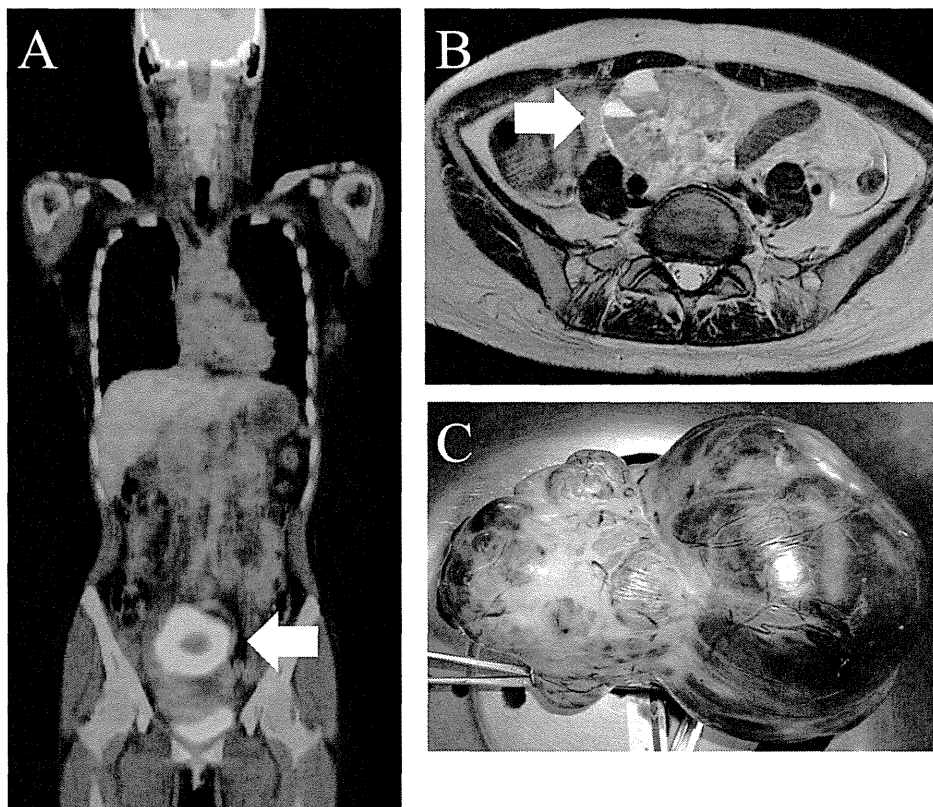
Ovarian metastasis of lung cancer. (A) PET-CT showing the large intrapelvic mass (arrow) of the patient. (B) Pelvic MRI revealing an ovarian tumor (arrow) with solid and cystic portions that displaced the uterus to the right with a negative beak sign. (C) The excised left ovarian tumor.
